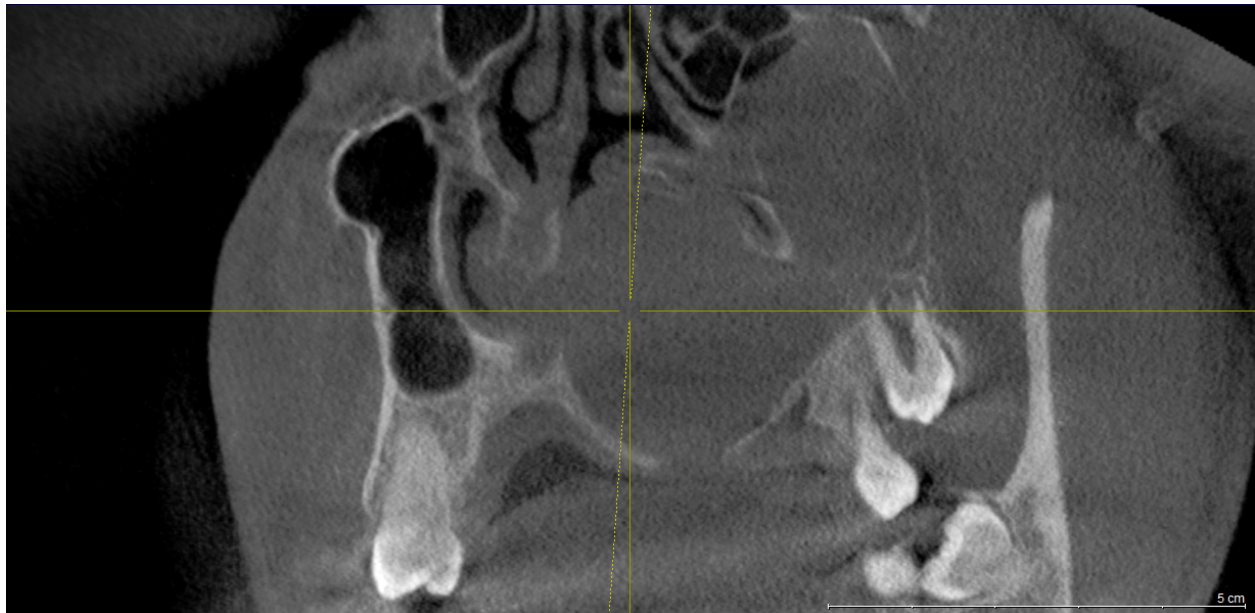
CBCT scan of a NPDC extending posteriorly into the nasal fossa
